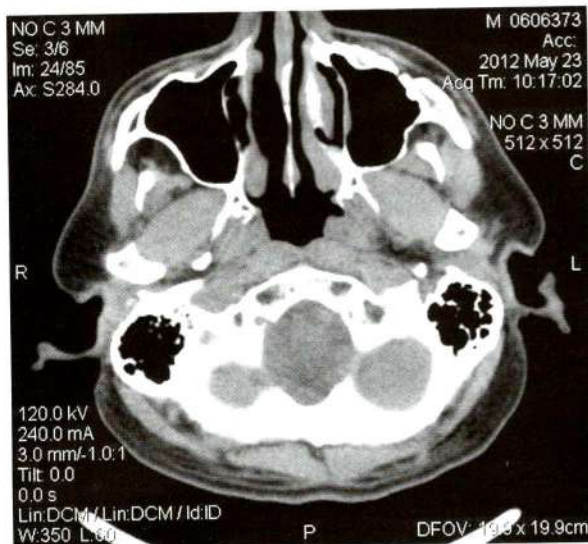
Axial non-contrast CT scan showed excessive fat filtration at bilateral cheeks
